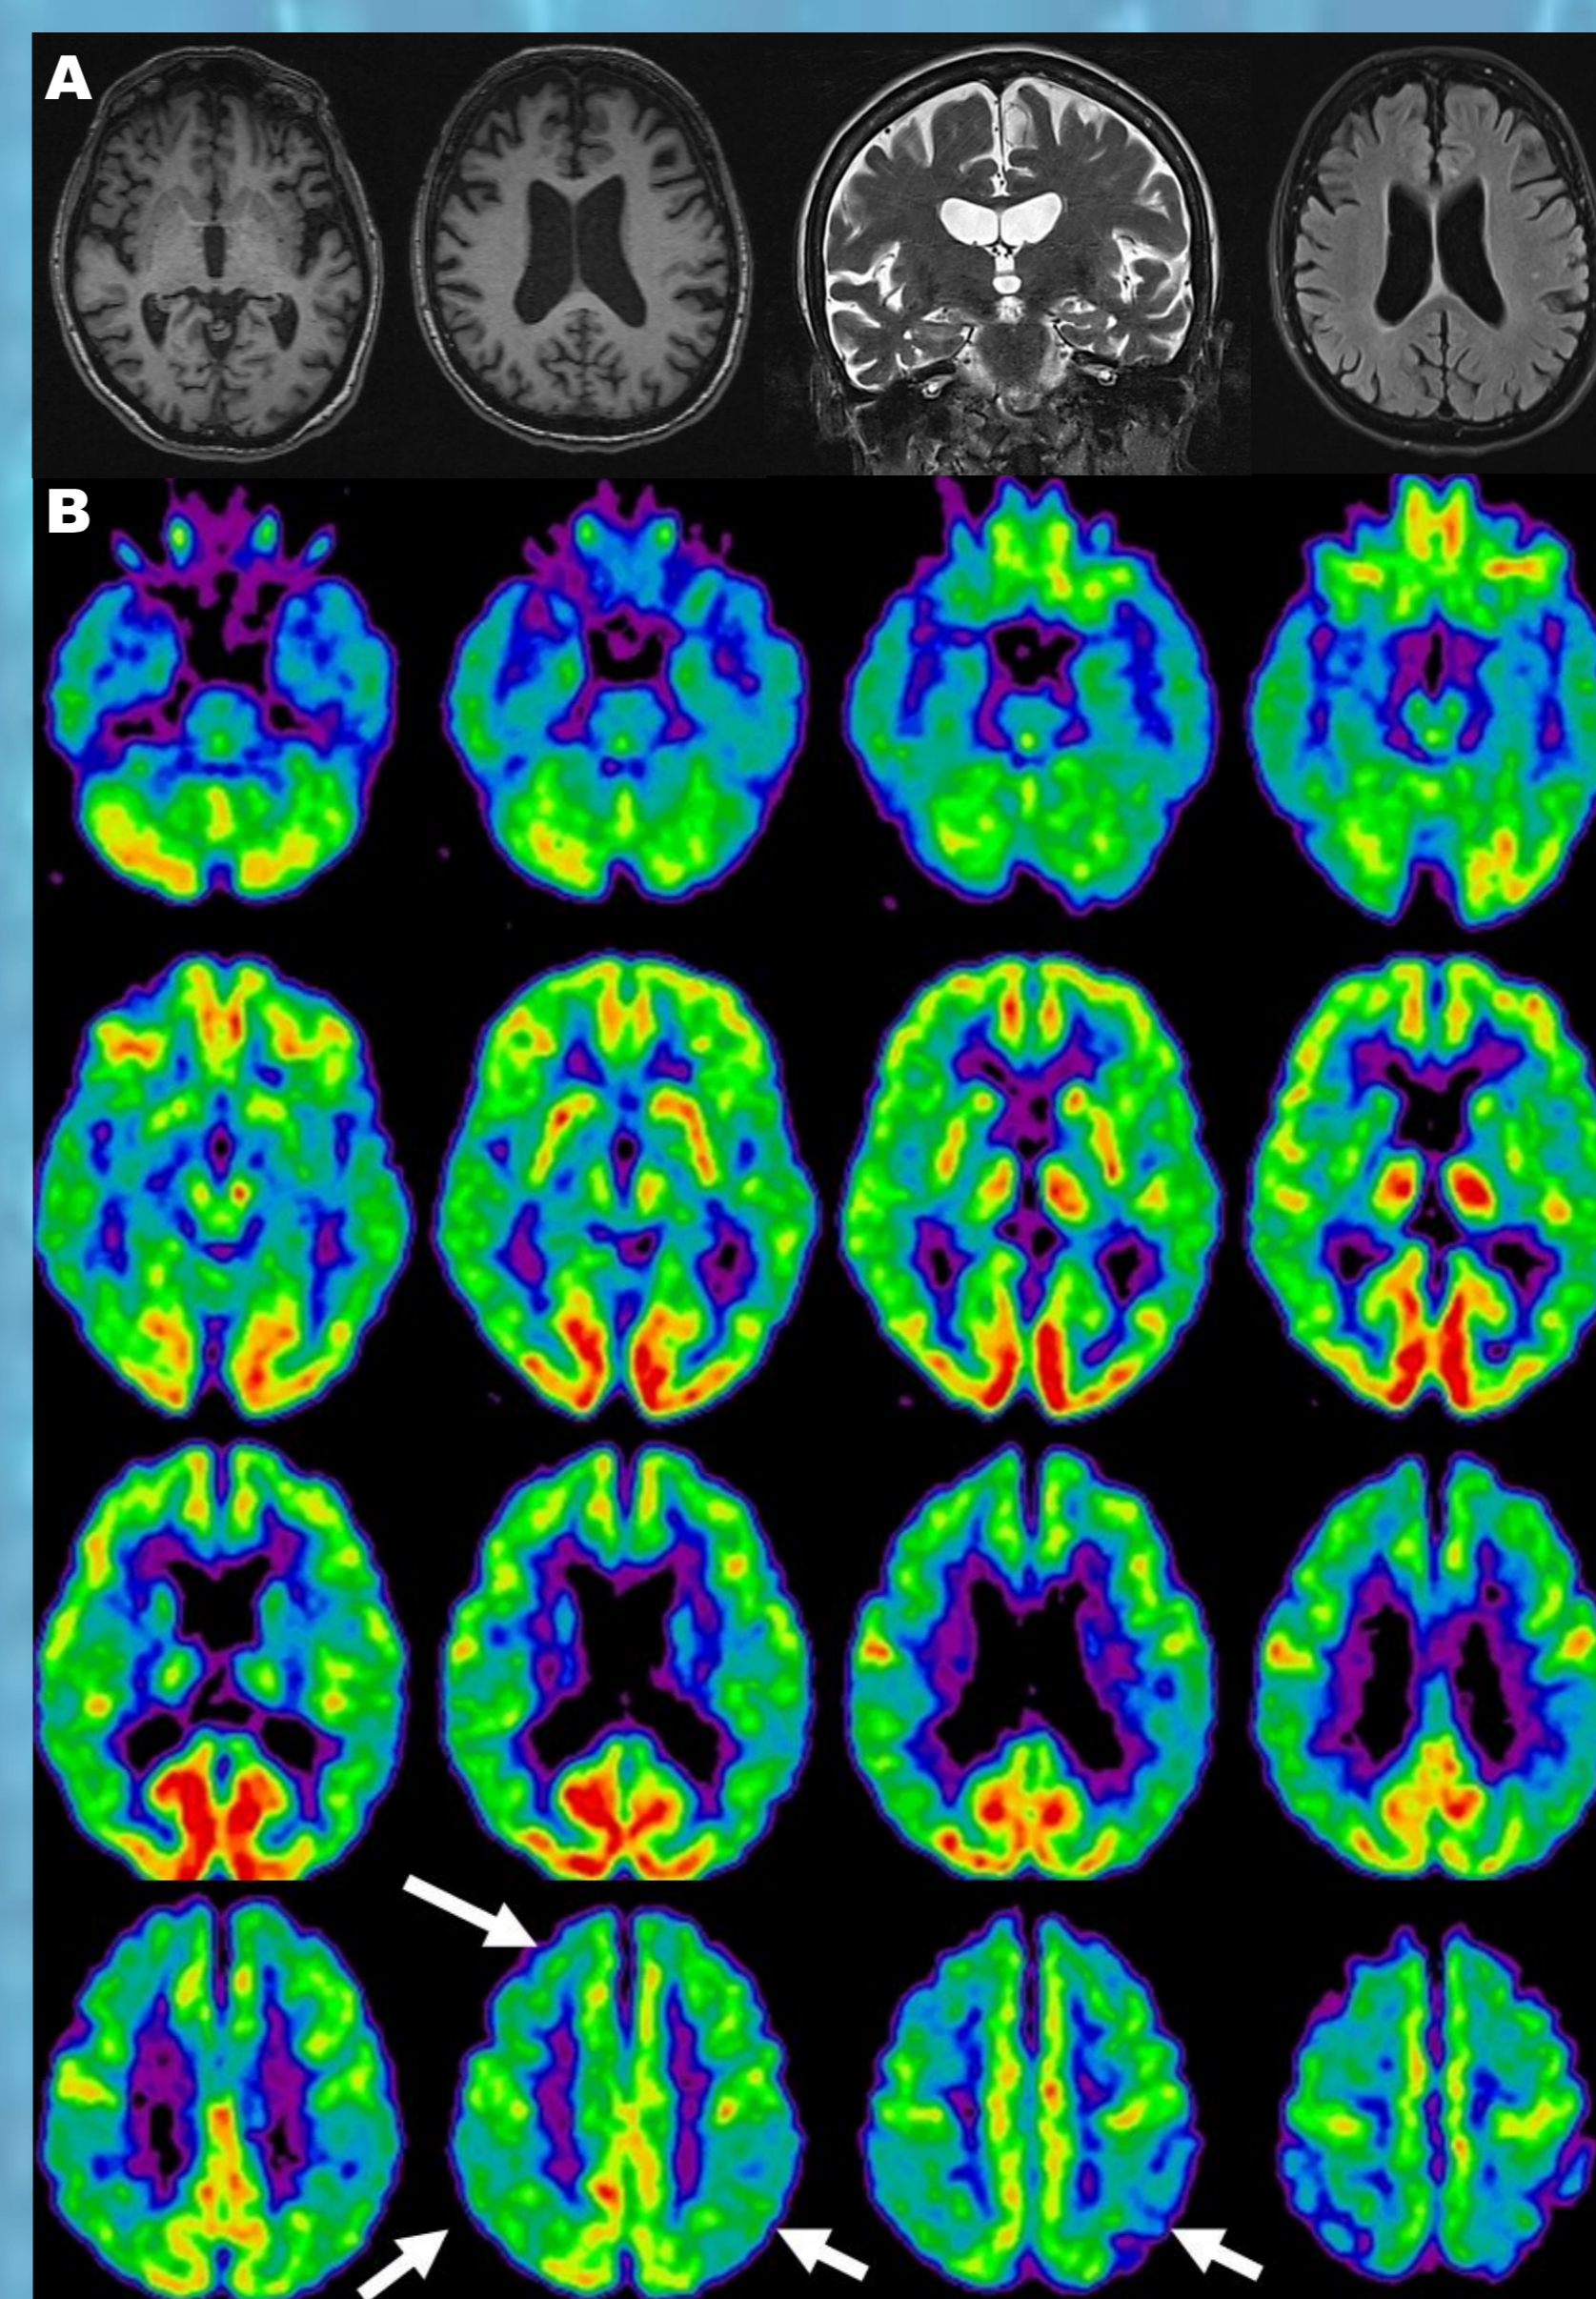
A: T1-weighted axial, T2-weighted coronal and FLAIR axial MRI scans showing a moderate, diffuse cortical atrophy, with very slight left hemispheric prevalence and without remarkable hippocampal involvement. B: ¹⁸F-FDG-PET disclosing hypometabolism mainly in superior parietal and temporo-parietal cortices, more marked on the left side, along with less evident hypometabolism in superior frontal cortex, prevailing on the right side (arrows). A slight reduction in glucose uptake is also evident in basal ganglia and thalami, especially on the right side.
